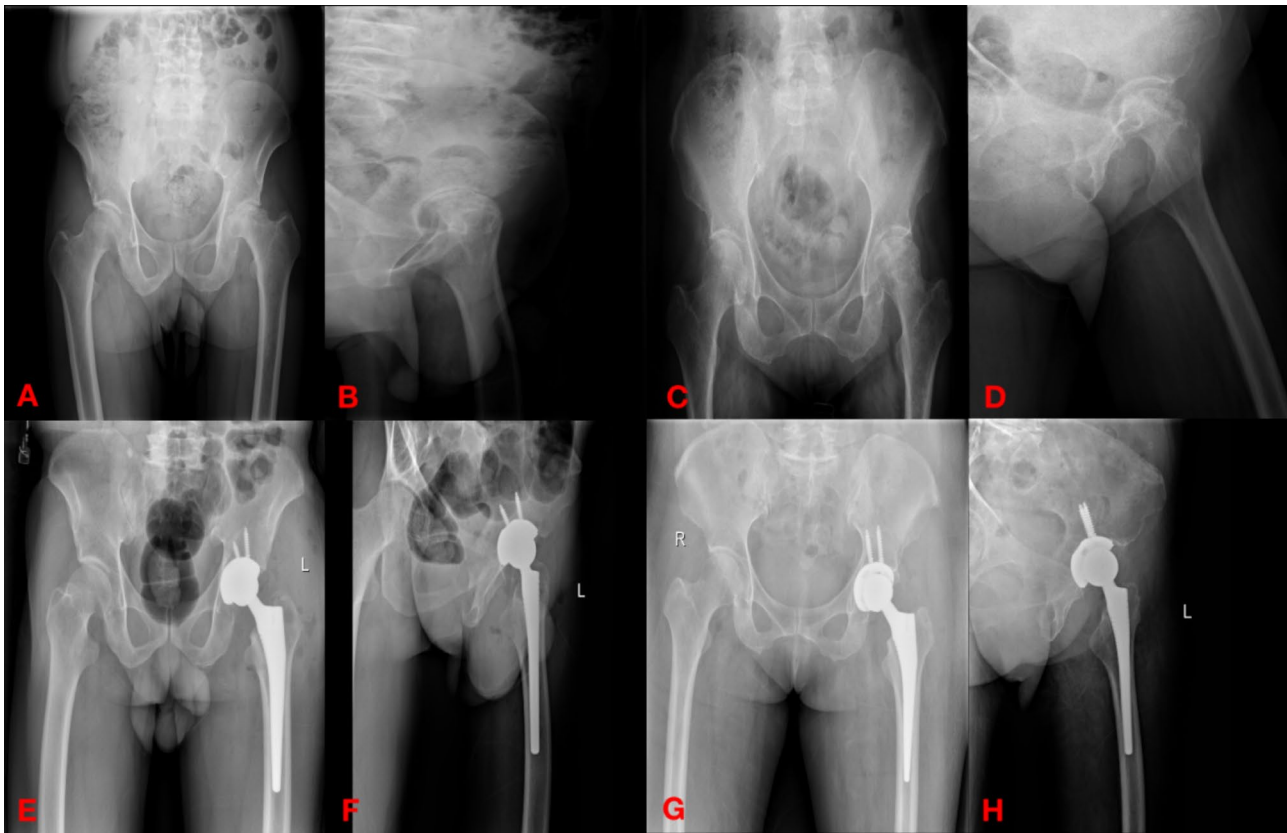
Preoperative and postoperative anterolateral X-rays of the hip. Note: (1) male, 64 years old, necrosis of left hip and femoral head. (A) Normal x-ray of preoperative hip; (B) x-ray of preoperative hip side; (E) Normal x-ray of postoperative hip; (F) x-ray of postoperative hip side. (2) Female, 66 years old, with necrosis of the left hip joint and femoral head. (C) x-ray preoperative hip position; (D) x-ray preoperative hip side position; (G) x-ray postoperative hip position; (H) postoperative hip side x-ray
